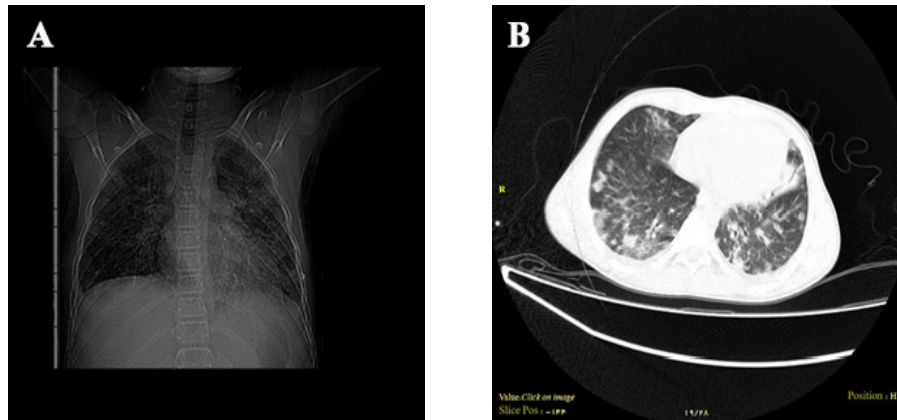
A): Chest radiograph and B) high-resolution computed tomogram of the lung of the presented case in the study.
